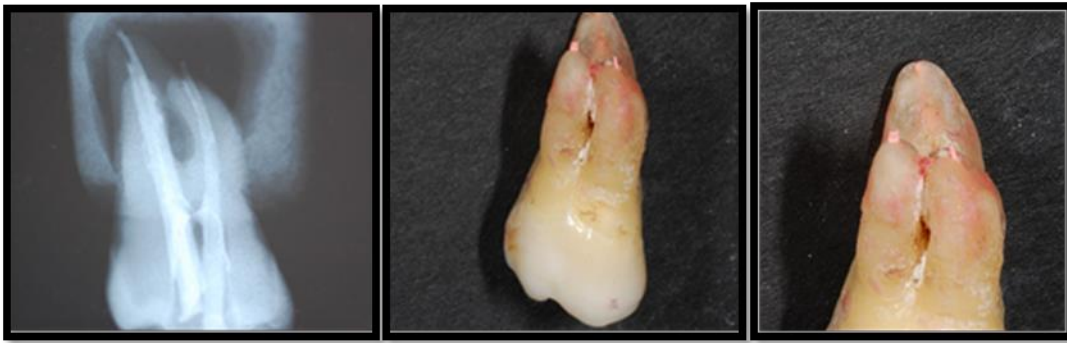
to 3-15c demonstrate a radiograph showing extruded MGP in the MB and DB canals, and it is confirmed when the tooth is removed from the resin block. The MGP in the palatal canal is slightly extruded although the radiograph shows it is just at the radiographic apex.
